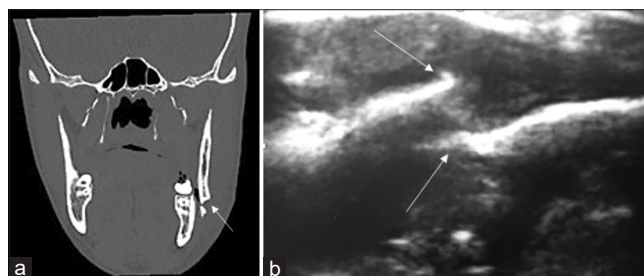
Computed tomography scan (a) and ultrasonography (b) images showing mandibular fracture.
